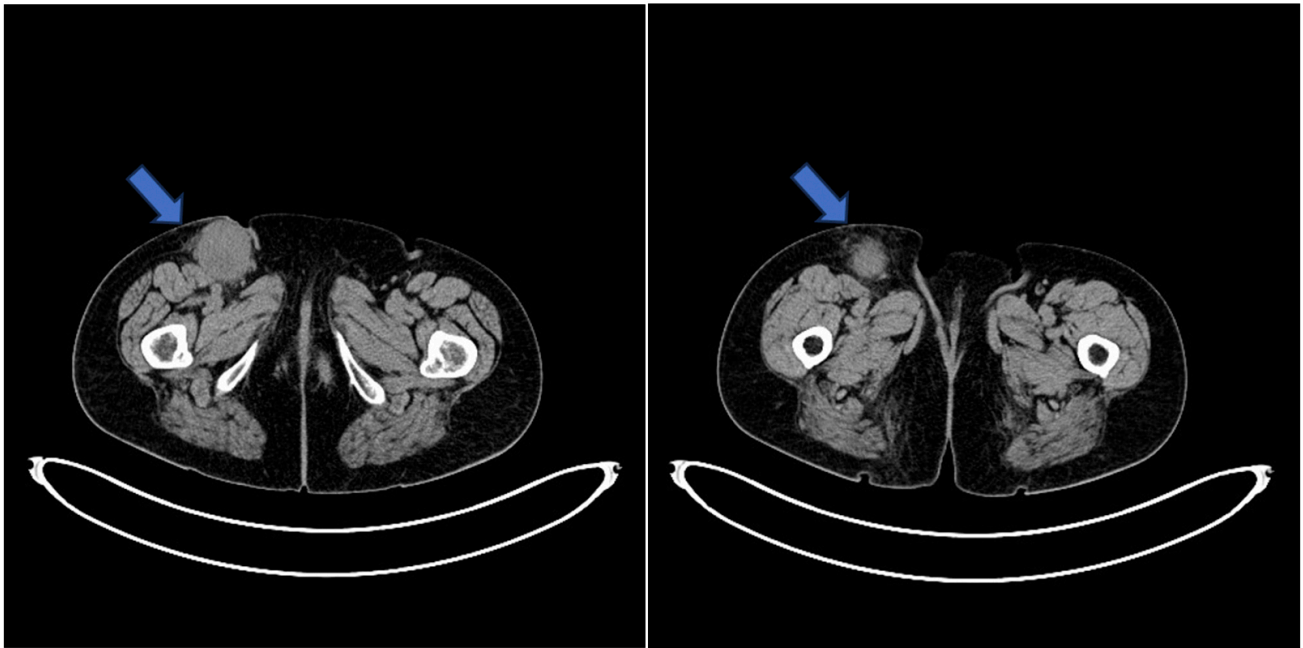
The large right inguinal lymph node shown on the CT scan. The blue arrows highlight the presence of inguinal lymphadenopathy. CT, computed tomography.
